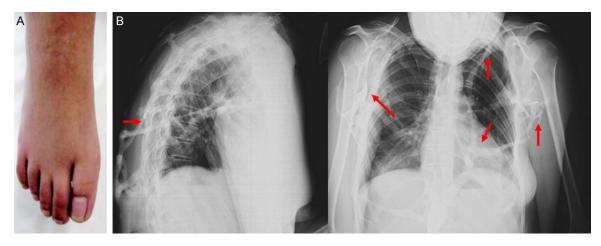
Photographs and image studies from patient 1. A. Congenital malformation of great toe was surgically corrected. B. Lateral and anteroposterior chest radiograph showing HO at the thorax and proximal humerus.
